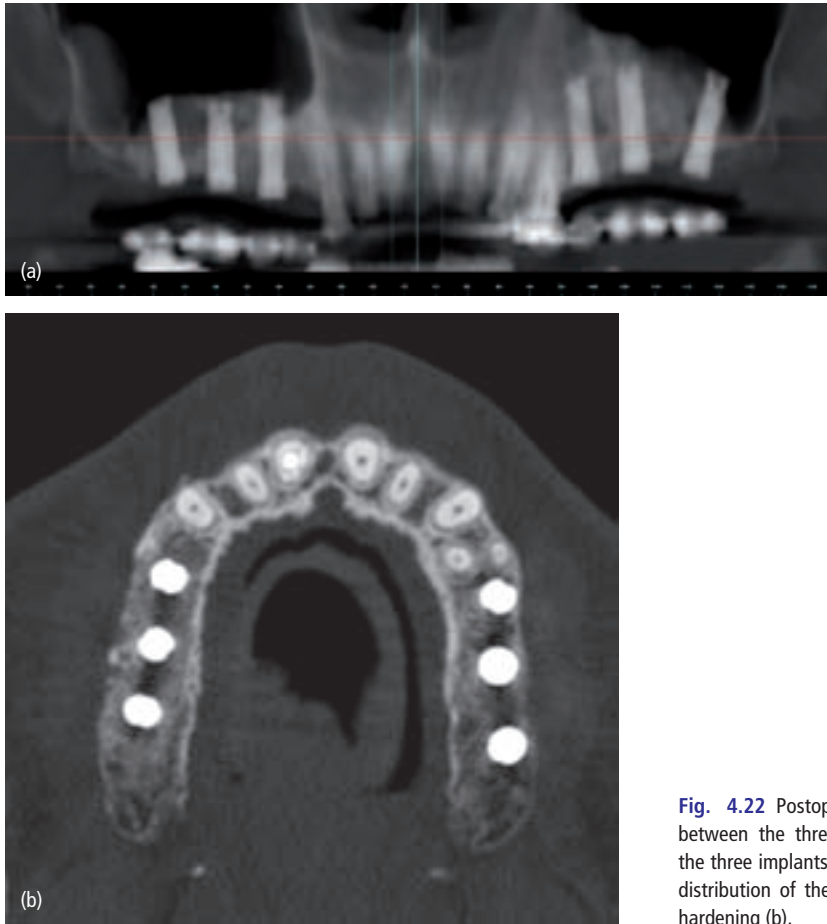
Postoperative panoramic radiograph showing a discrepancy between the three implants placed in the right sinus augmentation and the three implants placed in the left sinus graft (a); the axial view shows the distribution of the implants and the radiolucent artifacts known as beam-hardening (b).
